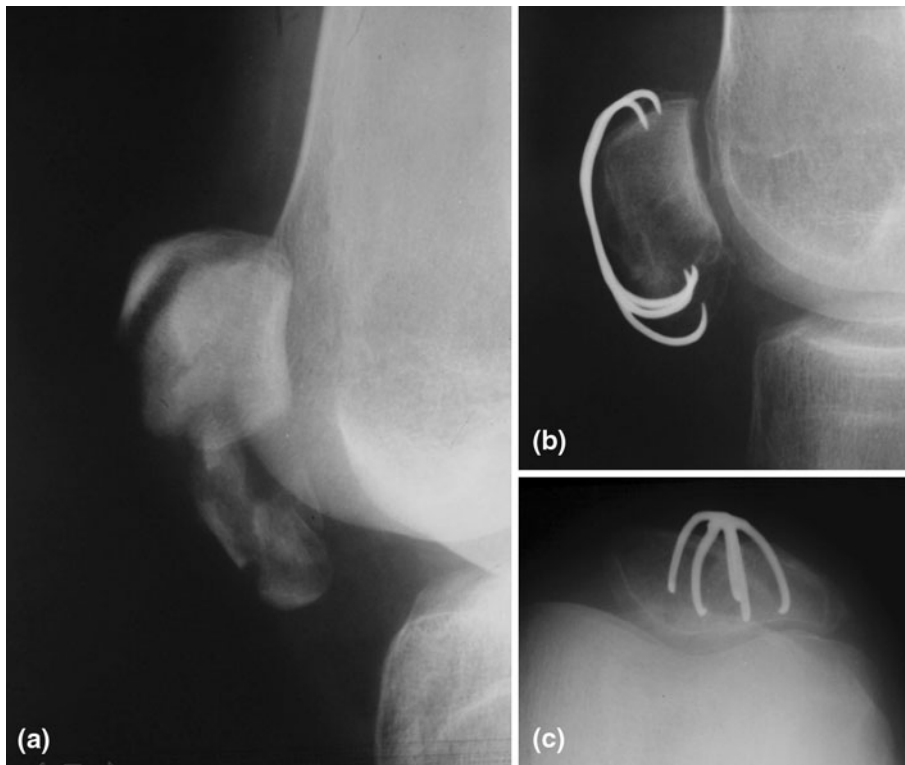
(a) Lateral radiograph showing displaced and comminuted fractures of the inferior pole. (b) and (c) Lateral and skyline radiographs, respectively, showing the comminuted fragments reduced and fixed by the PSMF
